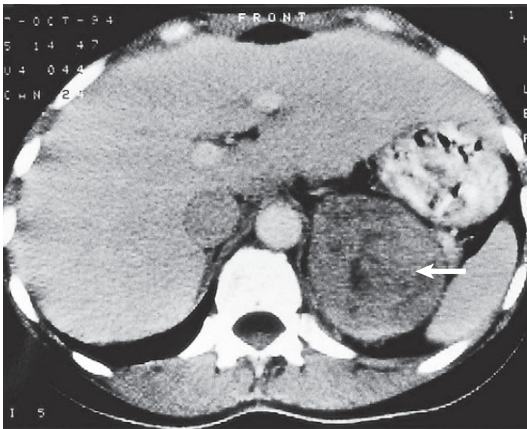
An abdominal CT scan showing a large phaeochromocytoma (arrow) in the left adrenal gland.
